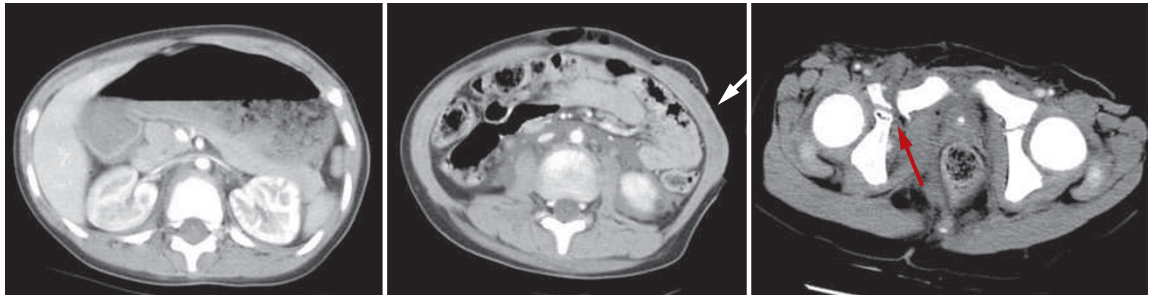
Initial CT of the abdomen. The scan was unremarkable except for a skin defect (white arrow) and a fracture of the right ilium (red arrow) with hematoma formation.
